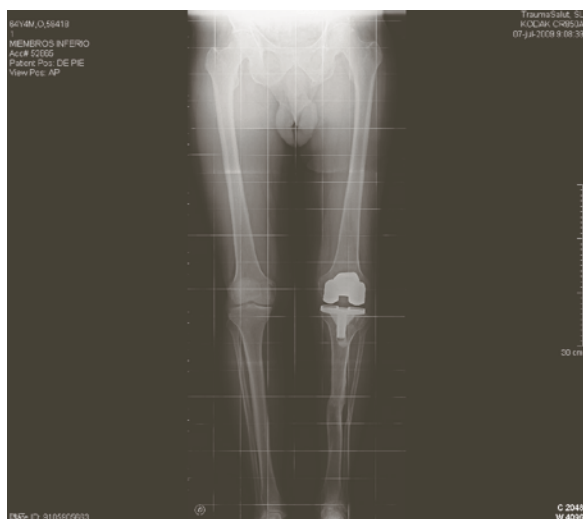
Anteroposterior (a), lateral (b) and axial (c) radiograph showing a well aligned total knee arthroplasty without radiolucencies after 2 year follow-up
